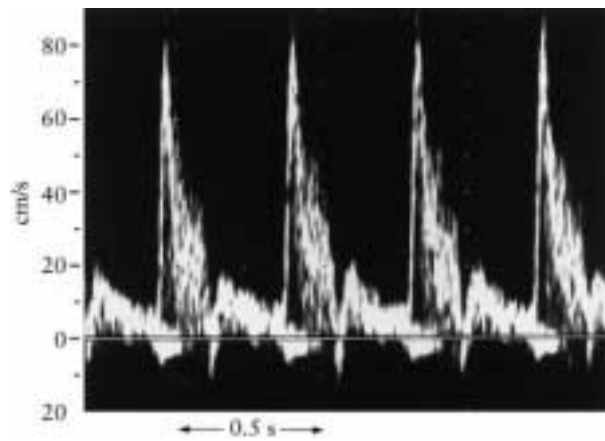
The characteristic Doppler flow velocity waveform obtained from the proximal branch of the pulmonary artery in the human fetus.
